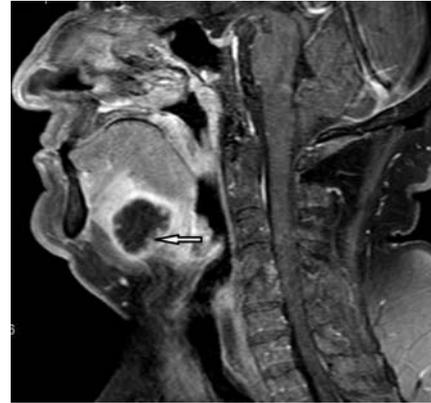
Sagittal T1-weighted MRI scan showing abscess at the base of the tongue (arrow)
